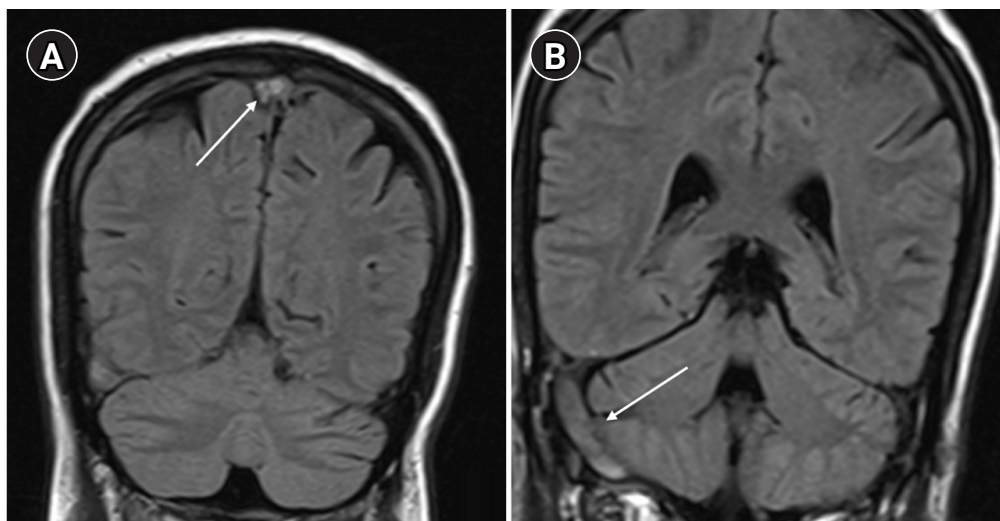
(A) Coronal and sagittal magnetic resonance imaging (MRI) brain images showing thrombosis of the superior sagittal sinus (arrow). (B) MRI brain image showing thrombosis of the right transverse sinus and sigmoid sinus (arrow).
